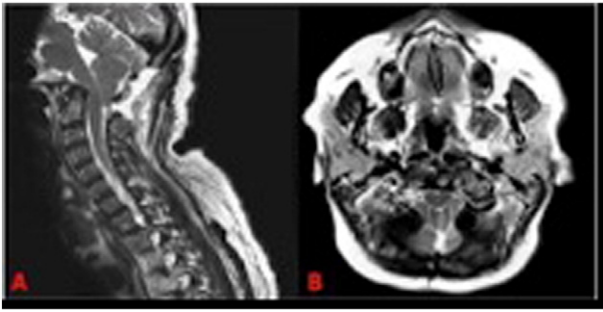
Pre-operative MRI of the brain and cervical spine. (A) Pre-operative sagittal and axial T2-weighted magnetic resonance imaging scans demonstrating a Type I Chiari Malformation with associated basilar invagination. (B) There is ventral and dorsal medullary compression by the odontoid process and cerebellar tonsils, respectively.
